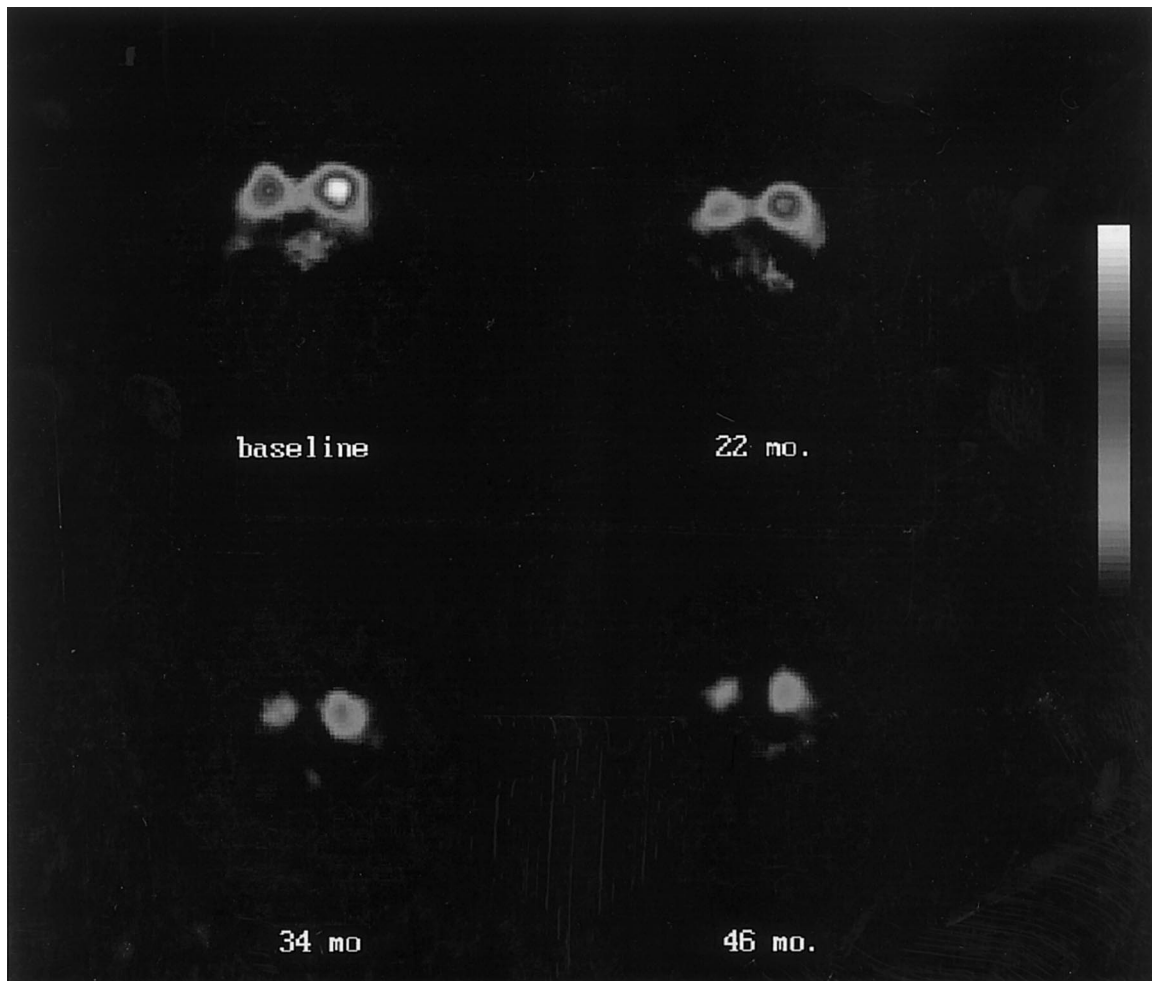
Parkinson disease patient imaged serially over approximately four years with ^{123}I β -CIT SPECT demonstrates serial reduction in radiotracer uptake in the striatum. Note relatively greater involvement in the putamen (posterior striatum) and left/right asymmetry of uptake which persists over four years.
